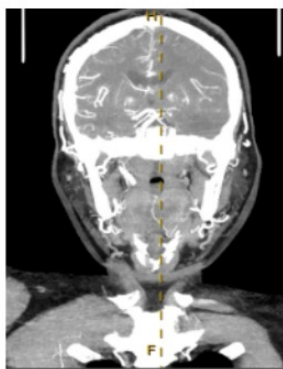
CT Head and Neck angiogram Coronal view. Shows Left PCA occlusion. Dashed Line corresponds to level of sagittal view in figure 2
